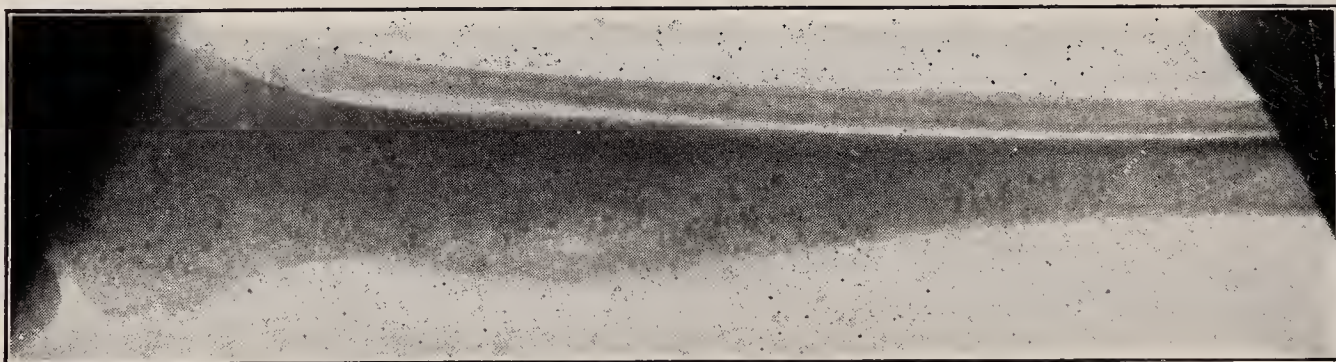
X-ray of syphilis of the tibia.
